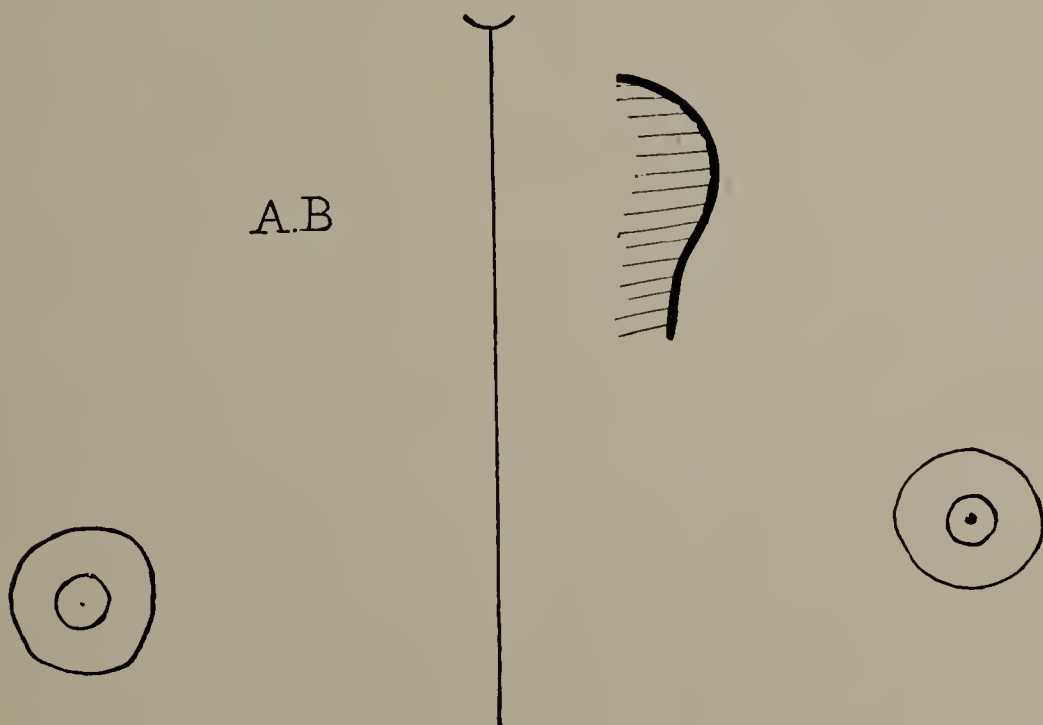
Case X. A. B. Cut of X-ray tracing. Aneurism of descending portion of aortic arch, recognized only by X-ray examination. Full line partially enclosing shaded area indicates aneurism.
